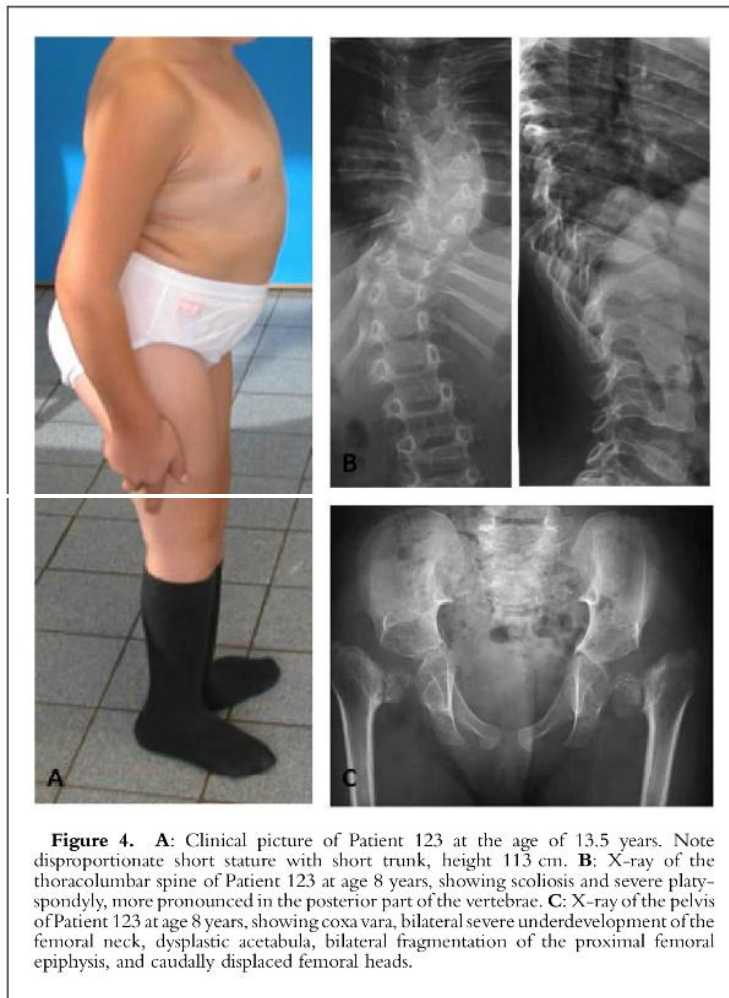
A: Clinical picture of Patient 123 at the age of 13.5 years. Note disproportionate short stature with short trunk, height 113 cm. B: X-ray of the thoracolumbar spine of Patient 123 at age 8 years, showing scoliosis and severe platyspondyly, more pronounced in the posterior part of the vertebrae. C: X-ray of the pelvis of Patient 123 at age 8 years, showing coxa vara, bilateral severe underdevelopment of the femoral neck, dysplastic acetabula, bilateral fragmentation of the proximal femoral epiphysis, and caudally displaced femoral heads.
